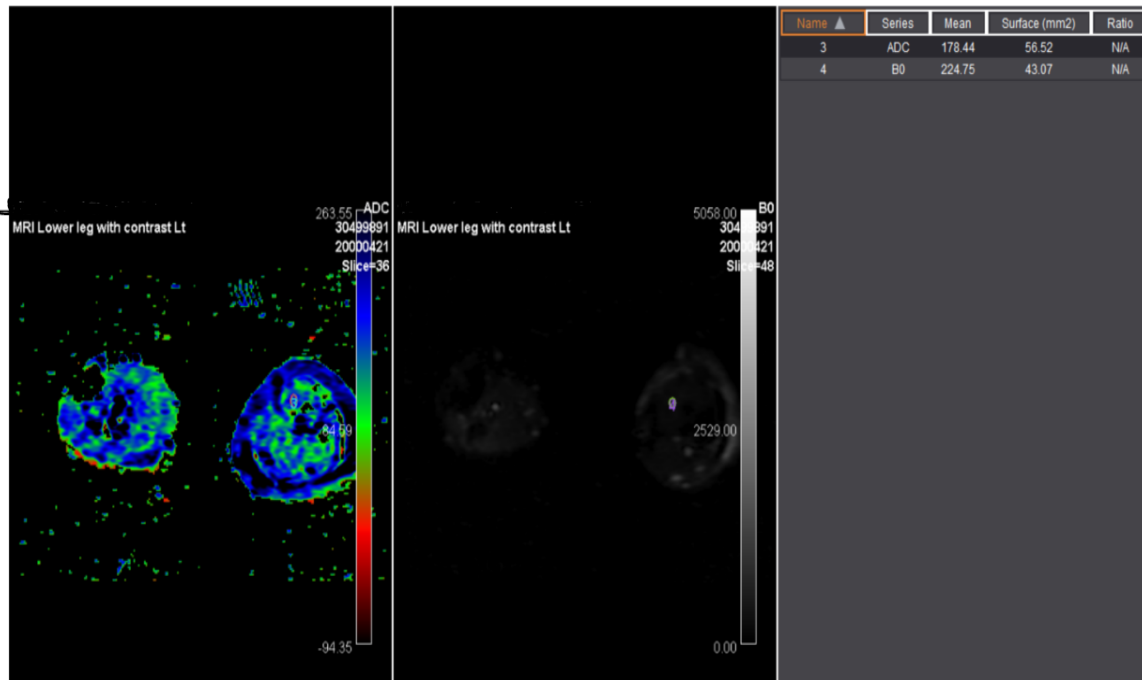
DWI sequence and ADC analysis: The ADC analysis includes the quantitative values of tissue diffusivity and diffusion restriction (ADC values) with the relevant curves and the cross sectional mapping of the ADC values (ADC maps)
